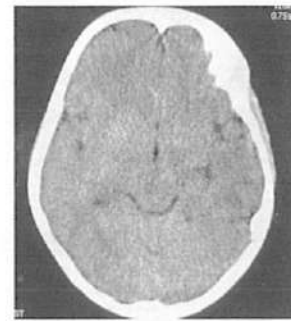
Hypodense area in the non-contrast computed tomography of the brain shows changes of cerebritis and encephalitis (red)
